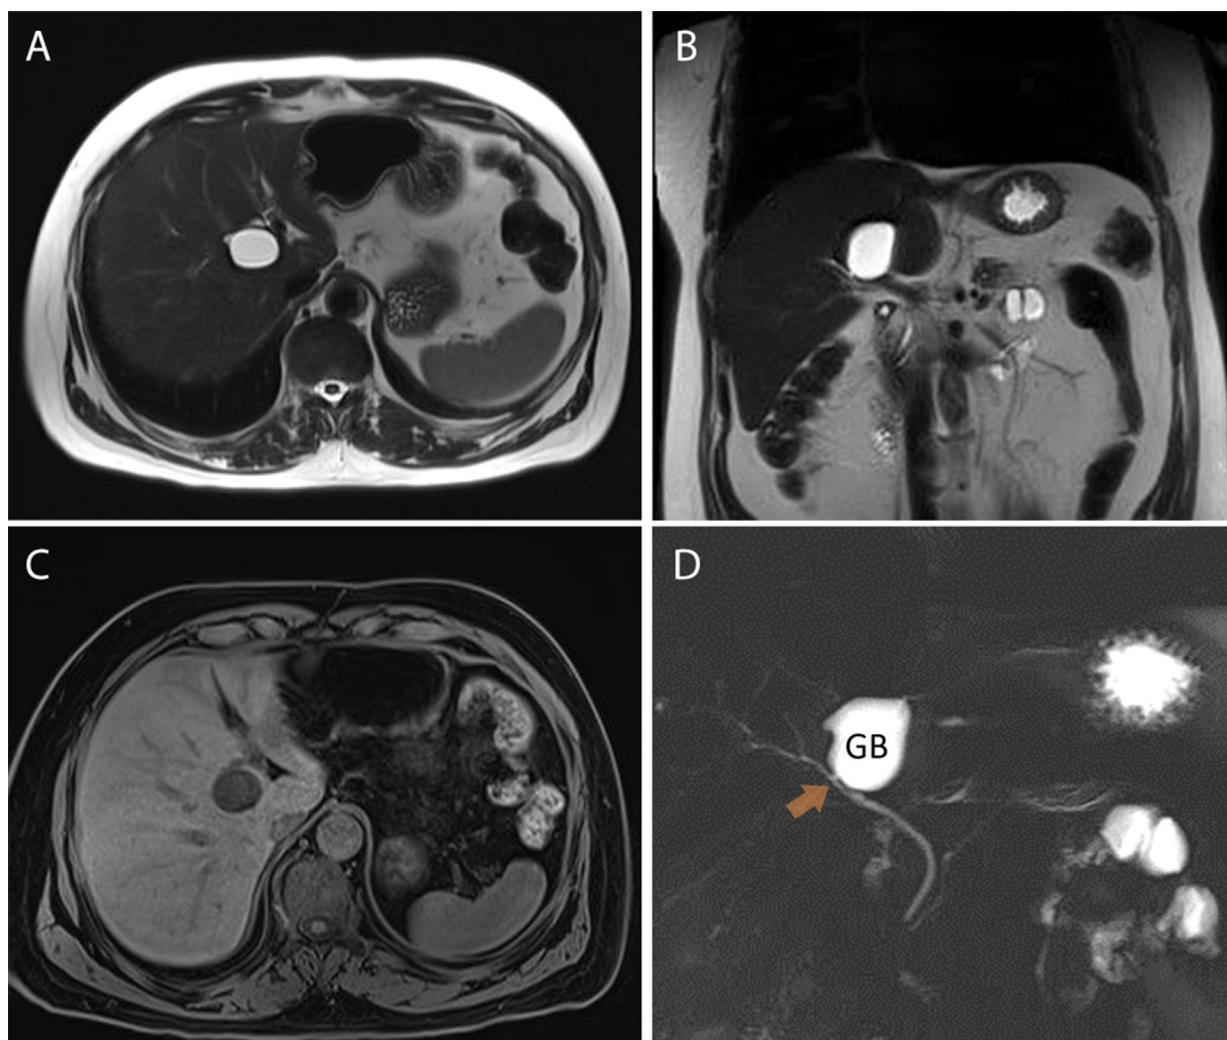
MRI of Liver. Magnetic resonance imaging study of the liver demonstrating an oblong shaped gallbladder in an ectopic position within the parenchyma of the right lobe of the liver on T2-weighted axial and coronal images (A, B) and axial T1-weighted image (C). MRCP confirmed the communication of the ectopic intrahepatic gallbladder (GB) to a normal biliary tree with a cystic duct emerging from the gallbladder as pointed by the orange arrow. (D)
